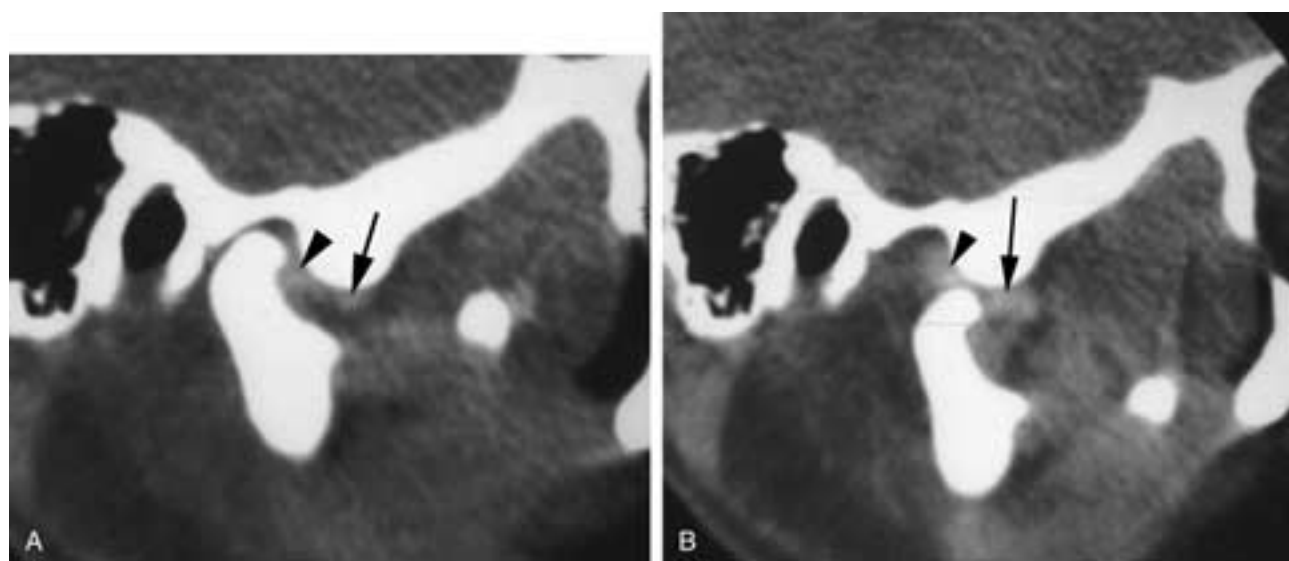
Direct sagittal CT. Anteriorly displaced disk with recapture (reciprocal click). A, Soft-tissue setting shows the condyle positioned posteriorly in the glenoid fossa. The posterior thick band (*arrowhead*) is demonstrated anterior to the condyle. The anterior thick band (*arrow*) is seen just inferior to the articular eminence. Normally, the condyle should articulate with the thin part of the disk visualized between the anterior and posterior thicker bands. B, Open-mouth position. The condyle now has a normal relationship to the disk articulating with the thin area between the posterior thick band (*arrowhead*) and the anterior thick band (*arrow*). The disk has been recaptured.
